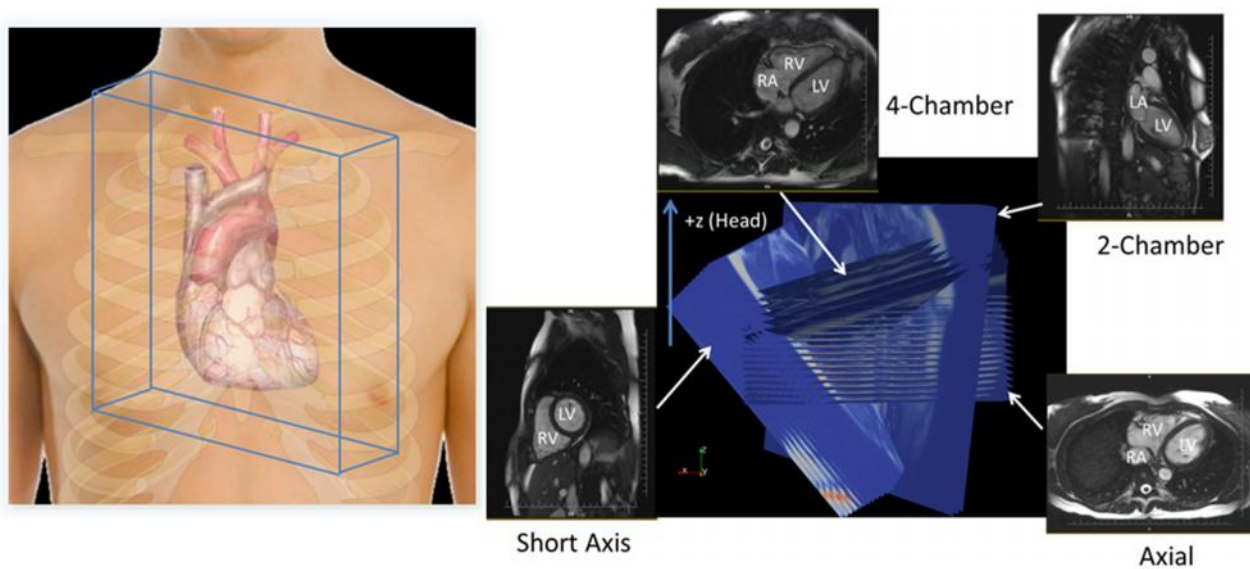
Orientation of 4DMRI rectangular prismatic field of view within subject's chest (Left) and orientation of a typical high-contrast, time-resolved 2D MRI image set (Right).
